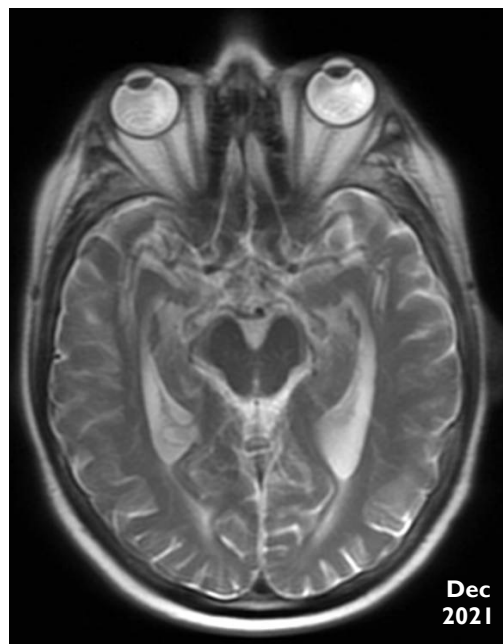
MRI brain following TCC resection
